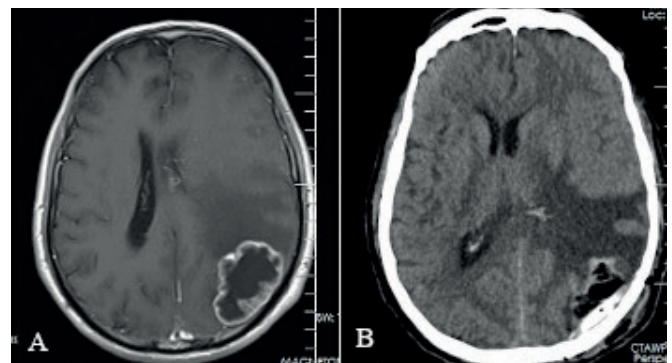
MRI and CT scan of metastatic brain tumor (A: preoperative scan of occipital metastatic tumor, B: Postoperative scan)
